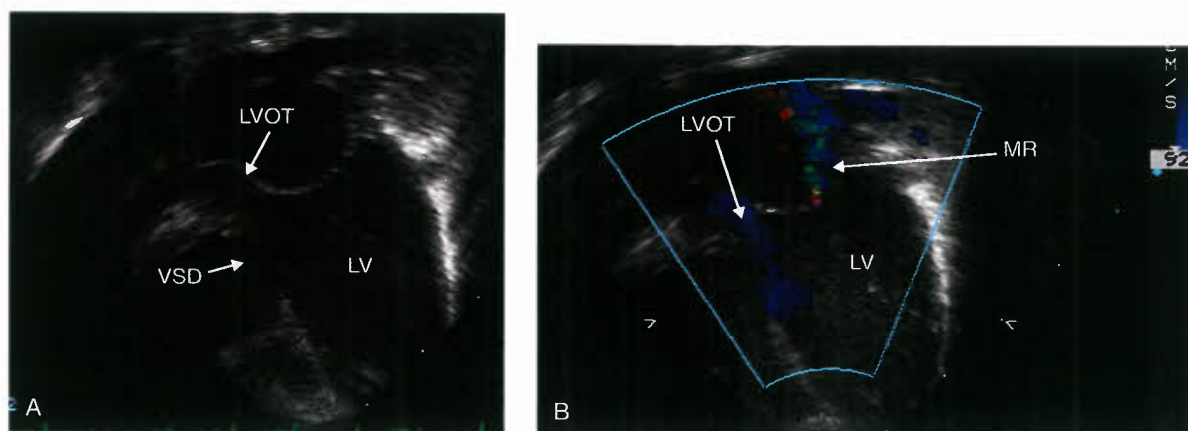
A: Apical long-axis view of a large posteriorly malaligned VSD. Note the resultant narrowing of the left ventricular outflow tract. The LV is dilated due to pulmonary overcirculation. B: Apical long-axis view demonstrating color Doppler flow through an unobstructed, but narrowed left ventricular outflow tract due to posterior deviation of the interventricular septum in the setting of a malalignment VSD. Note the presence of mitral regurgitation.
